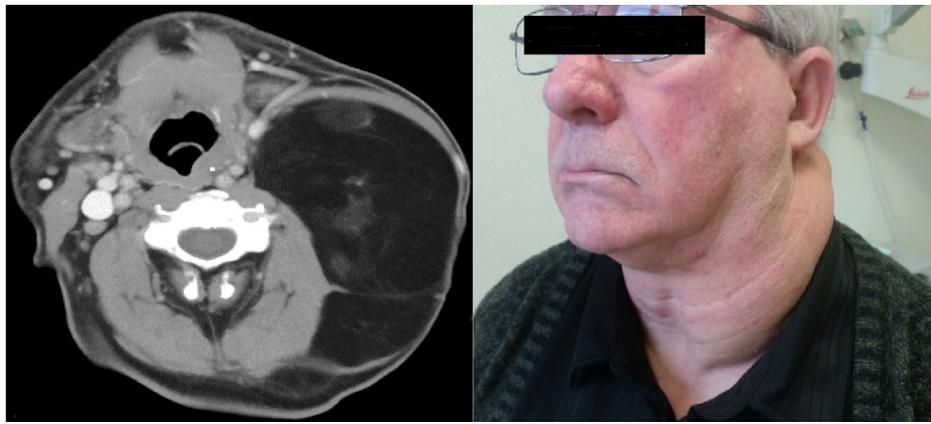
Left: CT scan and preoperative look of the nuchal lipoma with its almost 180-degree cervical extension. Right: patient preoperatively.
